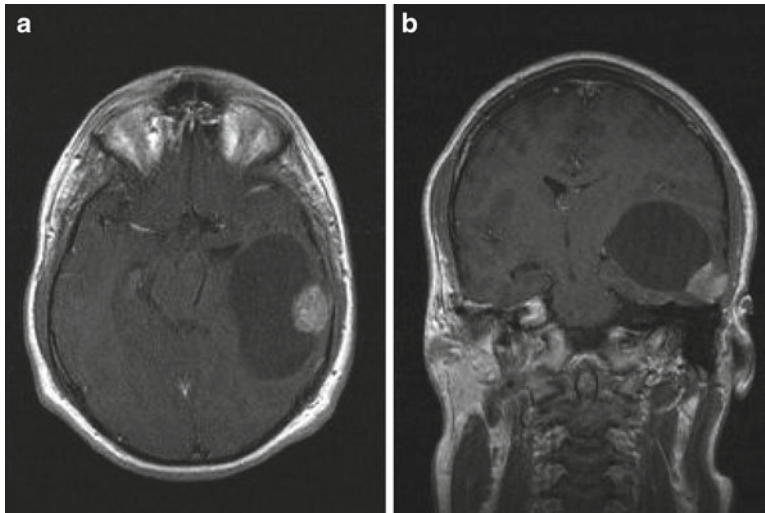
Magnetic Resonance Imaging of gangliogliomas. Large cystic ganglioglioma in the left temporal lobe. (a) Axial T1-weighted image after administration of intravenous gadolinium shows the large cystic tumor
